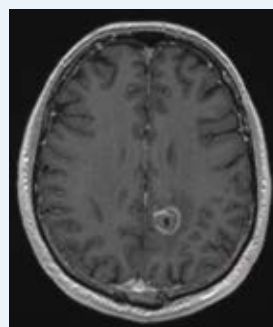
Six-month postoperative MRI with contrast showing decreasing rim of ablation enhancement and overall reduction in lesion size.
